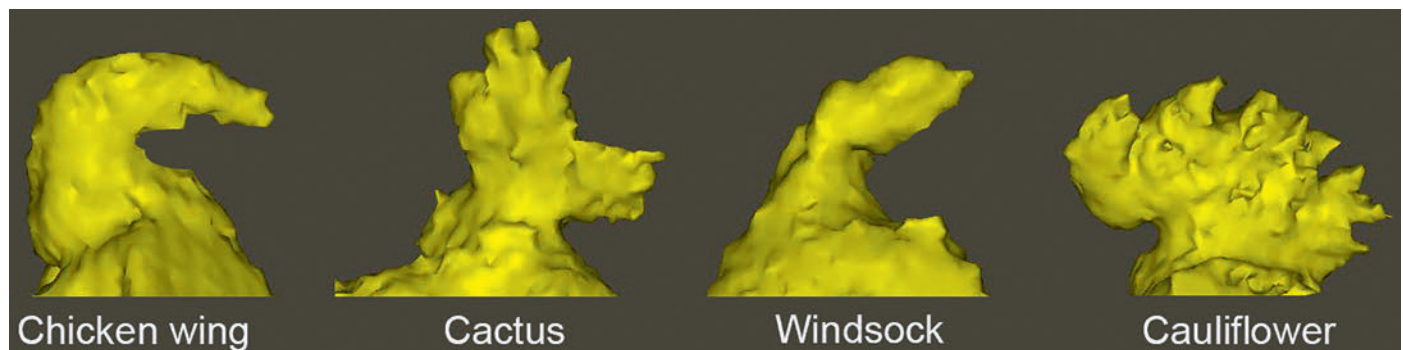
Morphological Types of the Left Atrial Appendage (LAA). Segmented computed tomographic images of the LAA in four different patients.
